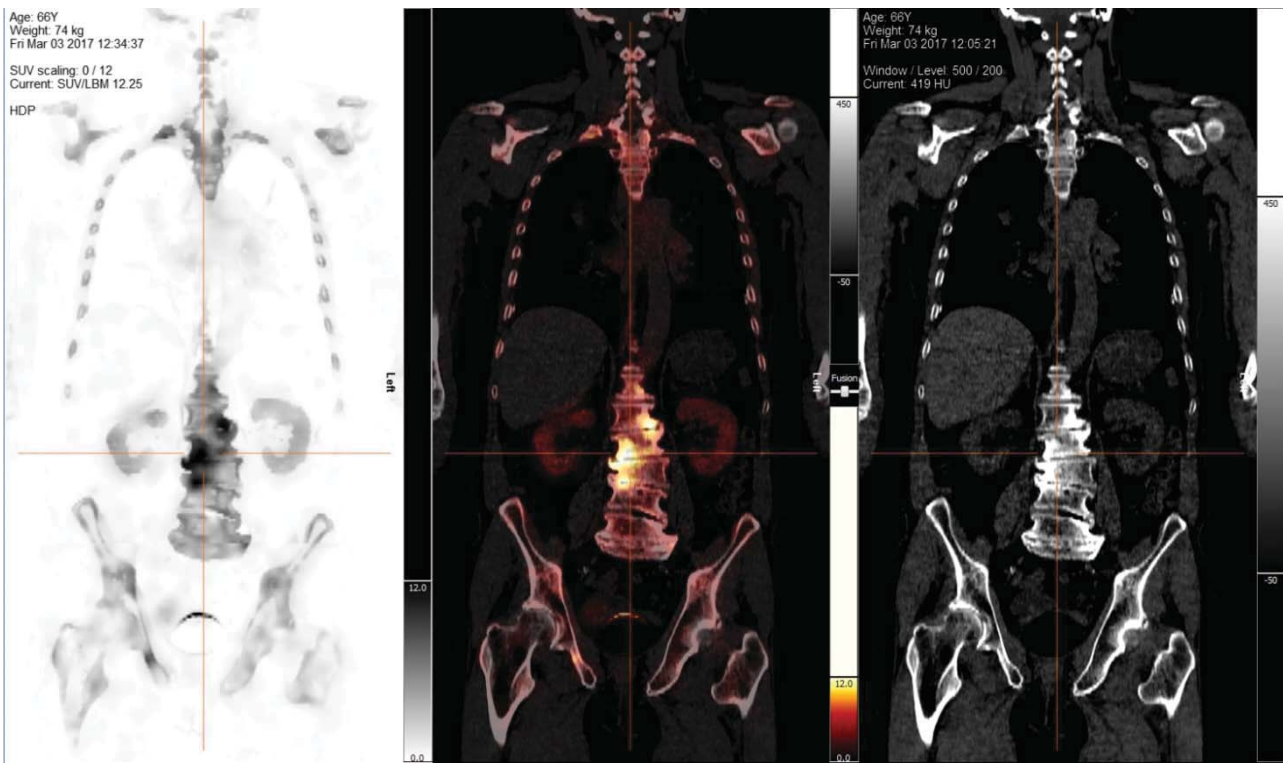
Case 3: SPECT image, SPECT/CT image and CT image (degenerative changes on the lumbar spine)
